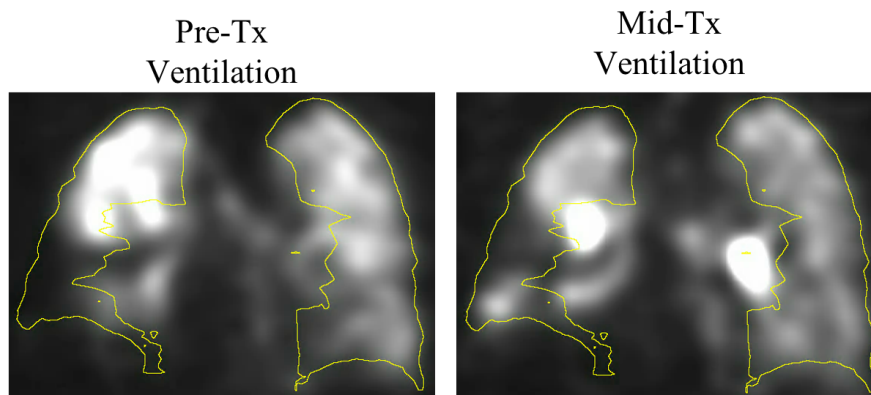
Example ventilation SPECT images at pre- and mid-treatment for patient VA029.
